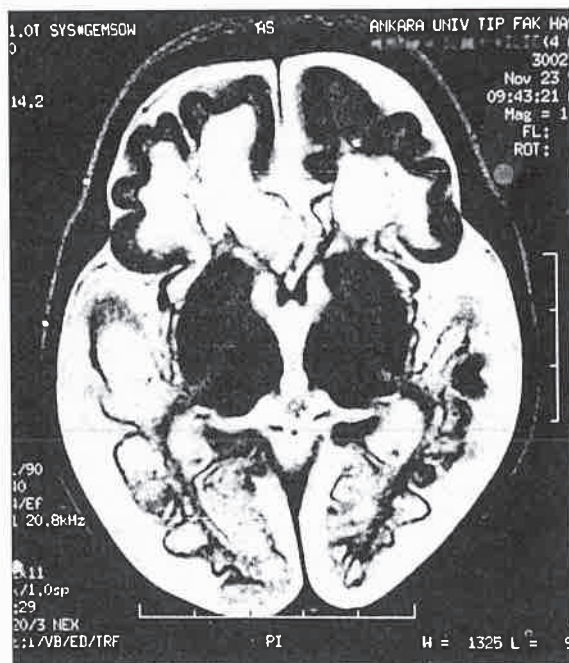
Cystic periventricular leukomalasia in both hemispheres, loss of volume in white matter, and cortical atrophy on T2 images in MRI at 4 months postoperatively
